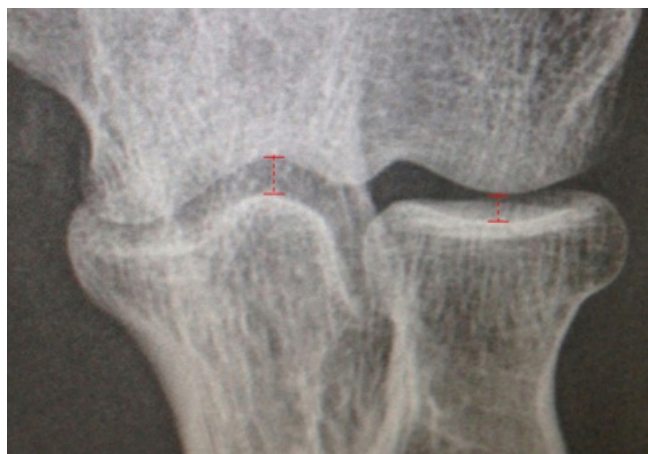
An anteroposterior radiograph was used to measure the joint space at the midpoint of the radiocapitellar and ulnohumeral joints.
